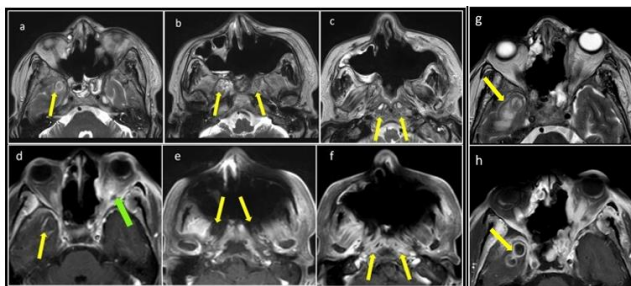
(a-f) Axial T2W and T1 post contrast images demonstrate: Right temporal lobe cerebritis (a, d), bilateral sphenoid wing osteomyelitis (b, e), diffuse enhancement of the soft tissue at skull base and pre vertebral space with abscess in the longus capitis(c, f). Also seen is left orbital cellulitis with proptosis (green arrow in d)., (g,h) Follow-up CE MRI in the same patient ,after 2 weeks, showed disease progression , but development of right temporal lobe abscess
